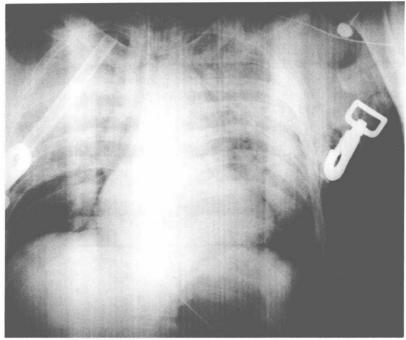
Same 37-year-old patient as in Figure 2. Three hours later chest radiograph reveals rapidly progressive pulmonary contusions, and the patient is at this point in severe hypoxemic respiratory failure. Note the left pulmonary hilum sign suggestive of a leaking torn thoracic aorta.
